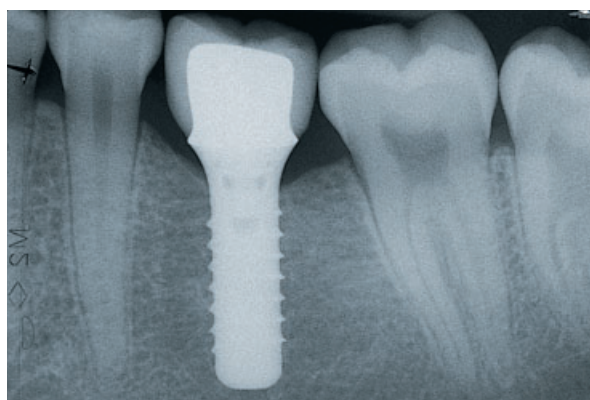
On the 1-year radiographic follow-up a diameter-increased ("wide-neck") implant can be noted which is essential for a suprastructure design without extremely open interdental embrasures, which would be prone to food retention and oral parafunctions.
